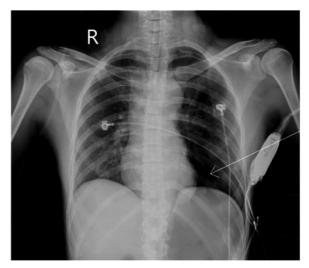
Chest X-ray shows increased density in the retrocardiac region and lucent area in the left lower lung field (arrow).
